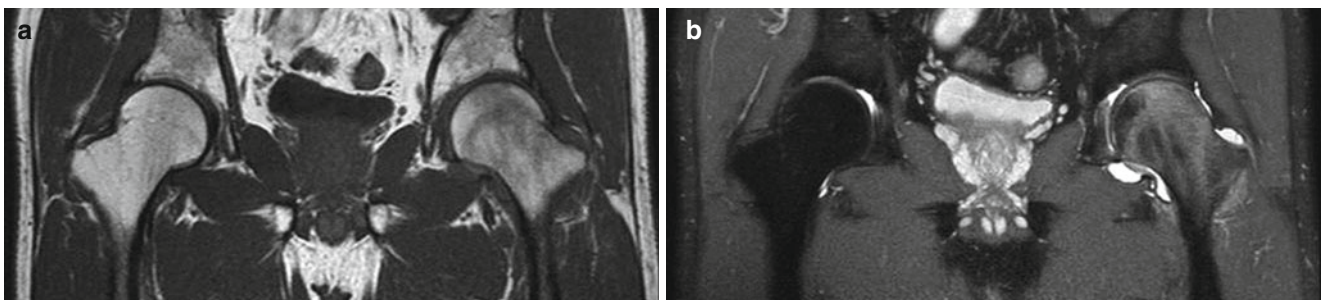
A 44-year-old man had left hip pain for 2 weeks. (a) T1-weighted spin-echo image (TR/TE: 450 ms/20 ms) reveals diffuse, low signal intensity in the left proximal femur. (b) On proton density
